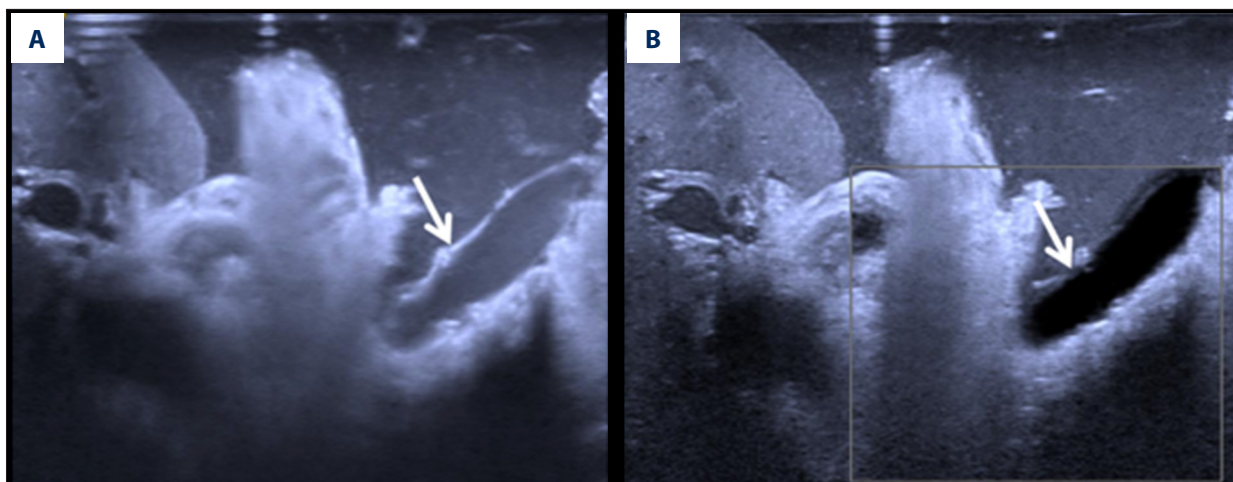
The anastomotic stoma of hepatic artery in an 8-year-old child using a Siemens S3000 device. Normal saline was filled around the hepatic artery. (A) Ordinary gray-scale ultrasonography showed the anastomotic stoma of hepatic artery (white arrow); (B) VET displayed the anastomotic stoma of hepatic artery (white arrow).
